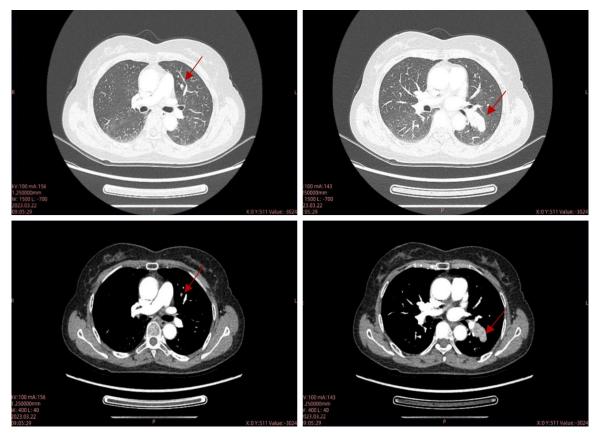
Initial chest enhanced CT scan of the lung window (top row) and mediastinal window (bottom row) revealed an occupied left hilum with smooth edges and enhancement, and a few small nodules in both lungs.
